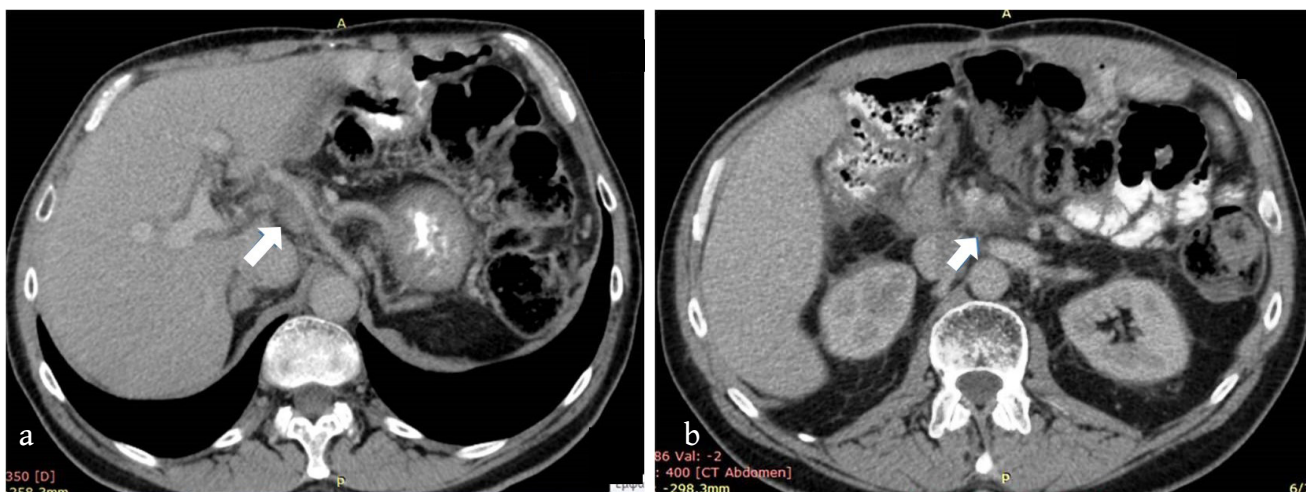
Contrast enhanced CT shows local recurrence of pancreatic cancer after total pancreatectomy along the hepatic artery (arrow in 2a) and posterior to the mesenteric vessels (arrow in 2b).
